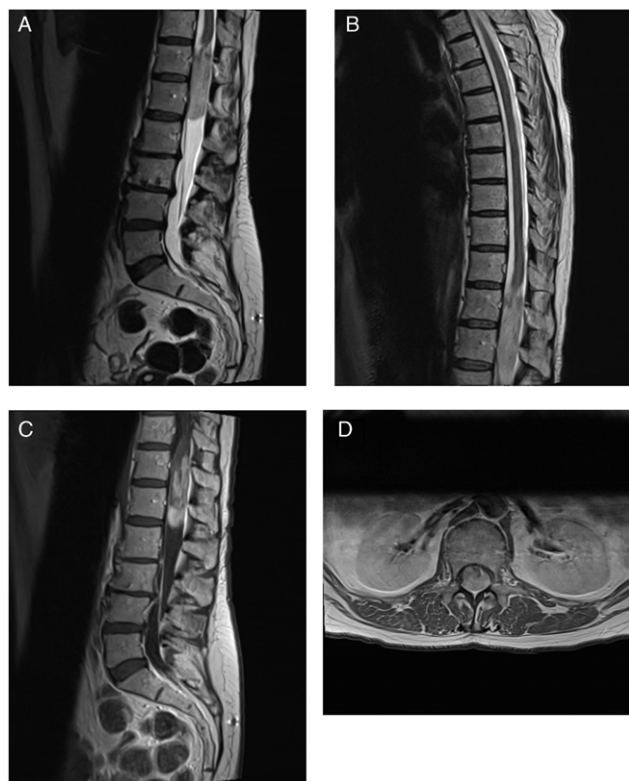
MRI of the lumbosacral spine, demonstrating an enhancing intradural extramedullary lesion centred at T12-L1 filling the thecal sac. (A, B) Sagittal T2-weighted imaging of the thoracic and lumbar spine. (C) Sagittal T1-weighted imaging of the lower thoracic spine with contrast. (D) Axial T2-weighted imaging at L1.
